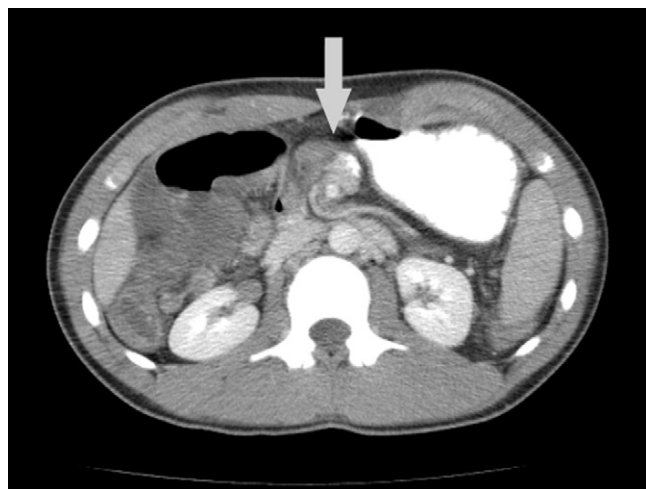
Computed tomography scan of malrotation with volvulus (note the spiral configuration of the mesenteric vessels [arrow]).
